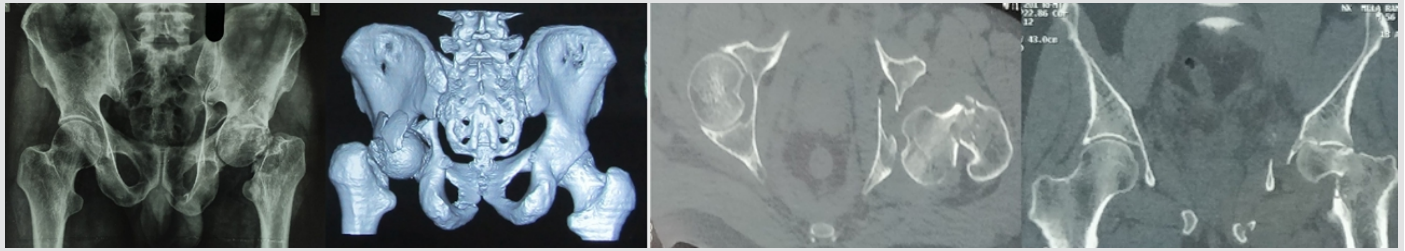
Pre-operative radiograph and computed tomography scan of a 56-year-old male showing fracture of the left acetabulum dome, wall, and column with associated fracture of ipsilateral femoral neck and impaction injury of the femoral head.
